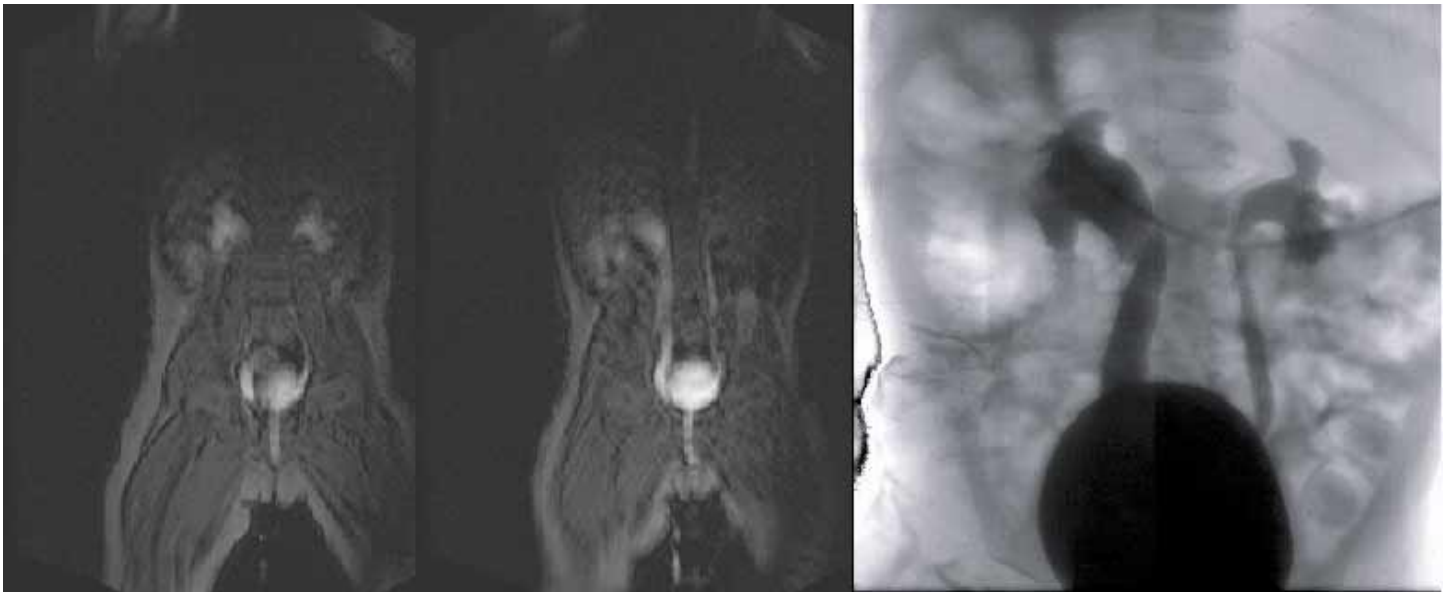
Left two images are from MR fluoroscopy, with the left image showing gadolinium in dilated renal pelvises and calyces bilaterally. Middle image reveals mild dilation of the ureter with no tortuosity, giving grade 4 on the right and grade 3 on the left. Right image shows similar findings by x-ray fluoroscopy.
